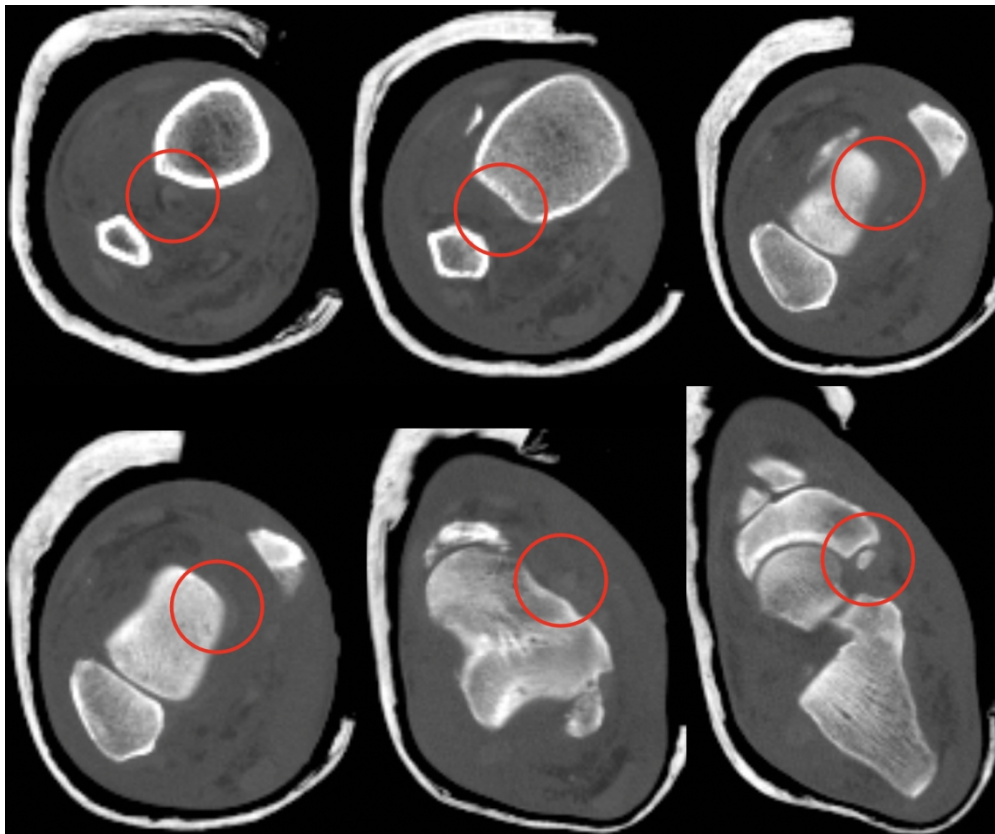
Axial CT sections of ankle (proximal to distal in direction of top-left to bottom-right) demonstrating PTT within the interosseous space proximally. The tendon enters the tibiotalar joint space distally, displacing the talus anterolaterally.
